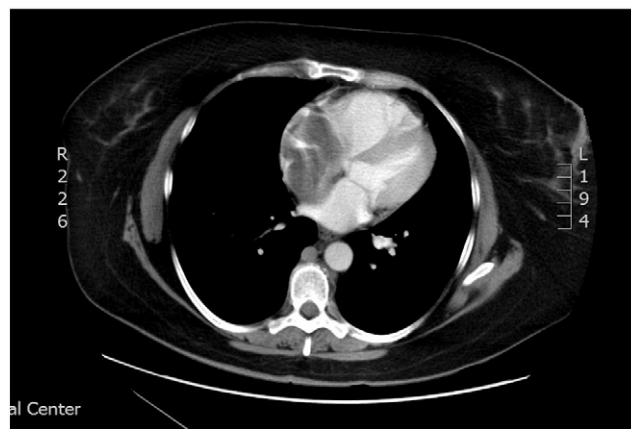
CT scan showing large soft tissue mass filling and distending the right atrium.
